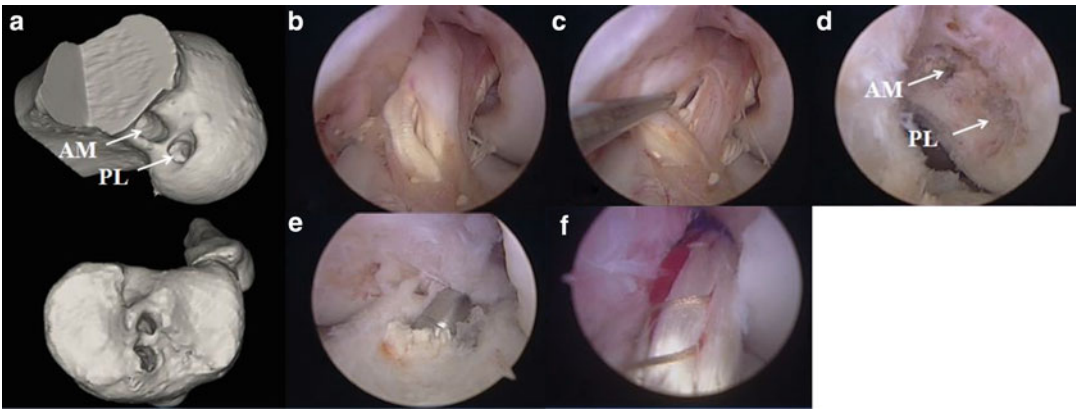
Anatomic single bundle revision surgery after a primary anatomic ACL double bundle reconstruction. Both tunnels in each insertion site were converted into one. (a) 3D-CT scan showing double bundle anatomic
